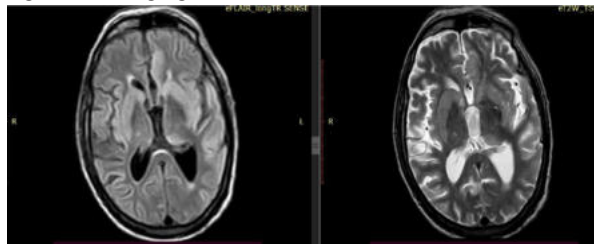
FLAIR SequenceFigure 2B:-T2W Sequence
